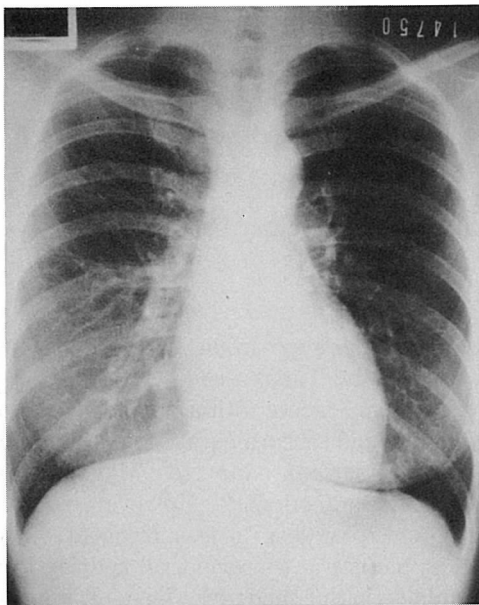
Chest x-ray examination on admission
